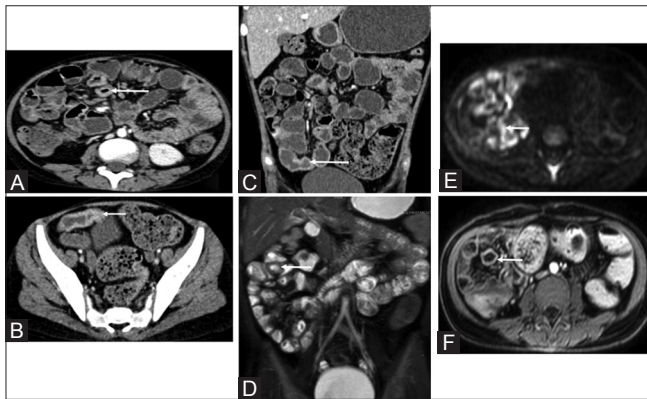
(A-F): Multifocal CD (active). Axial (A and B) and coronal (C) CTE images showing multiple noncontiguous segments of bowel wall thickening (thin arrow). Coronal T2-weighted MRE image (D), diffusion weighted b 800 axial image (E) and postcontrast image (F) confirm the multifocal involvement
